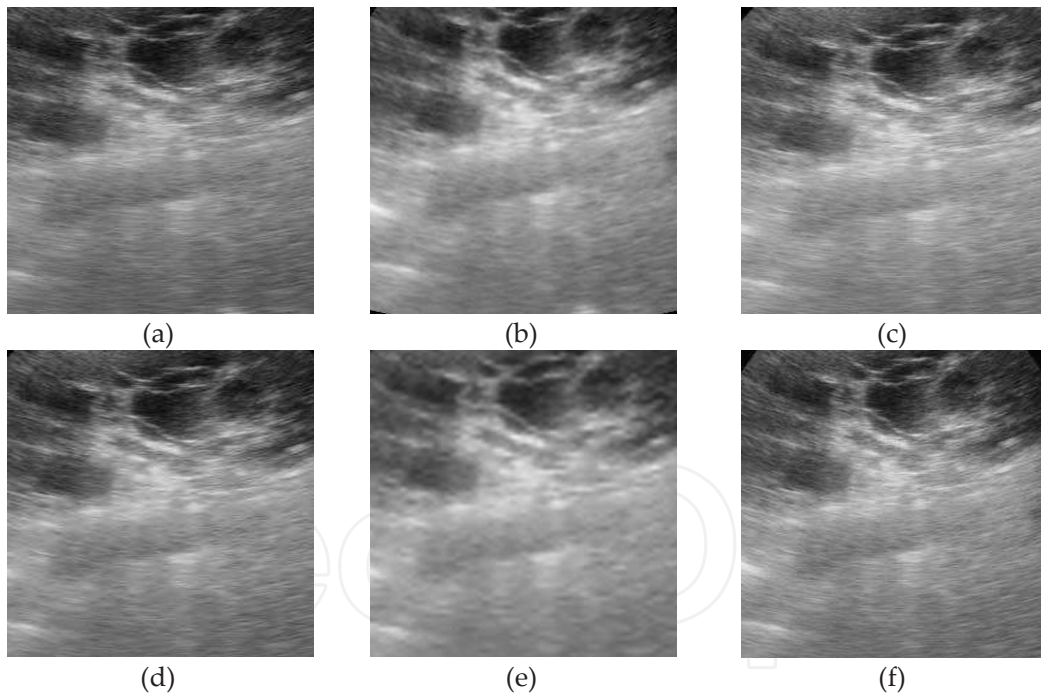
a) A sub image of original ultrasound image (b) sub image of despeckling using Wiener filter (c) sub image of despeckling using WT method (d) sub image of despeckling using CT method (e) sub image of despeckling using cycle spinning based CT method (f) sub image of despeckling using proposed linear regression model.
